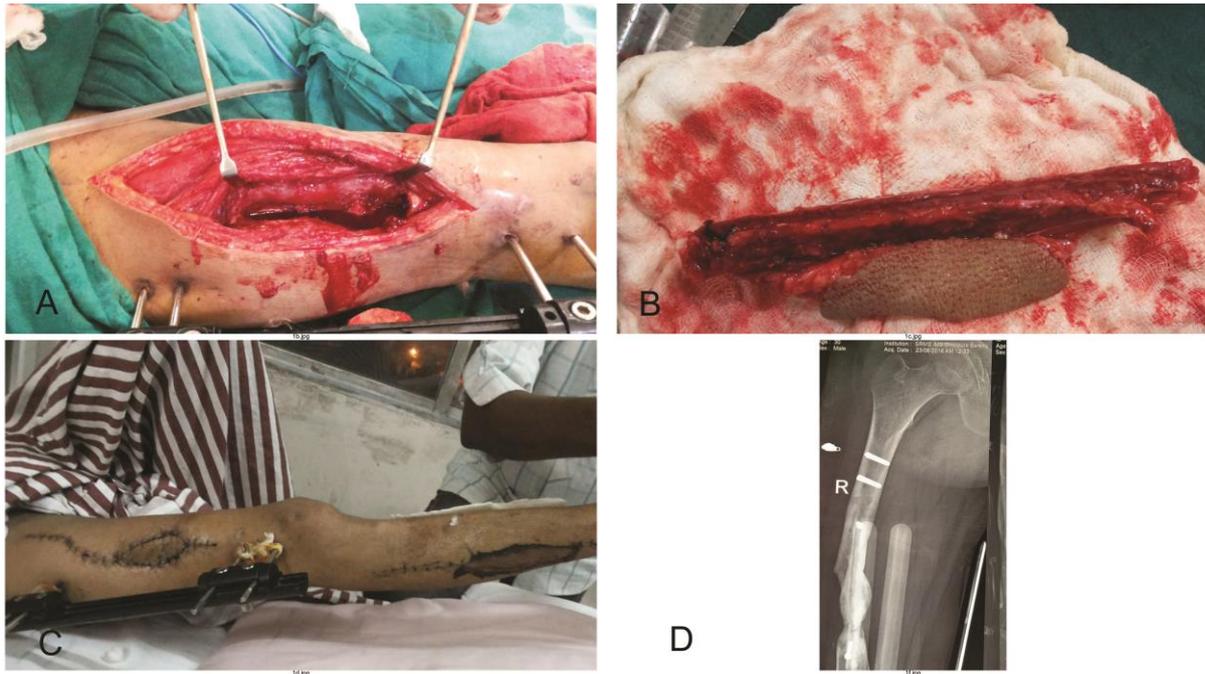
Free fibula flap for reconstruction of segmental defect of femur, (A) segmental femur defect, (B) harvested osteocutaneous fibula flap, (C) lap inset and donor site coverage demonstrated in same limb. Skin paddle is used for flap monitoring purpose as well as to close recipient site without tension and (D) post-operative X-ray showing significant bone hypertrophy at flap recipient site.
